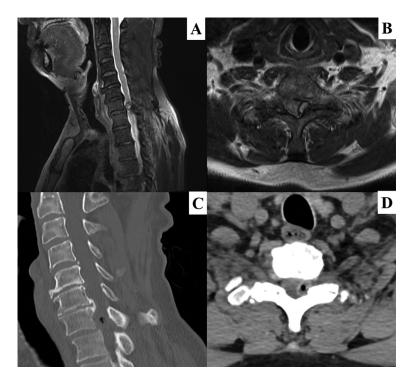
Magnetic resonance imaging. (A and B) Synovial cysts located at the posterolateral dural sac with a low signal intensity surrounded by a high signal intensity in T1W1. Computed tomographic scans. (C and D) Anterior C5 and C6 vertebral body osteophytes and posterior C6 and C7 vertebral body osteophytes.
